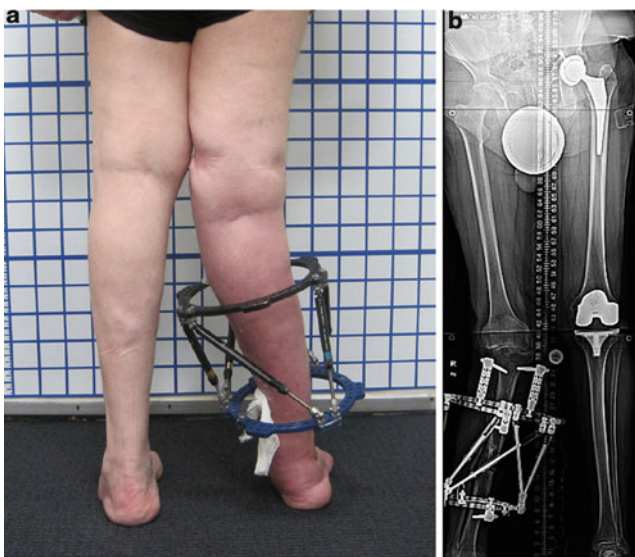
There was delayed healing of the tibia. The ankle fusion part of the frame was removed and the TSF was maintained. (a, b) Back view and standing X-ray showing correction of the tibia and ankle with residual deformity at the knee
